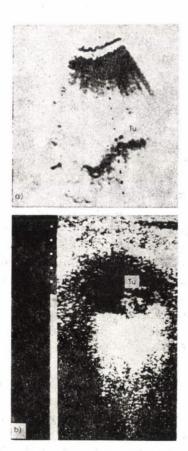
Nut-sized tumour on the left side of the bladder. a. Compound ultrasonogram; b. real-time transverse section scan
